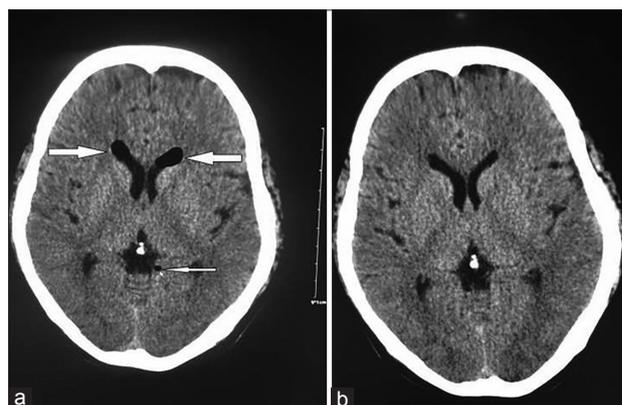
Axial view of nonenhanced cranial computed tomography scan. (a) Large air collection in the frontal horns of the lateral ventricles, and a smaller one in the third ventricle region (arrows); (b) No significant abnormalities 1 month later.
